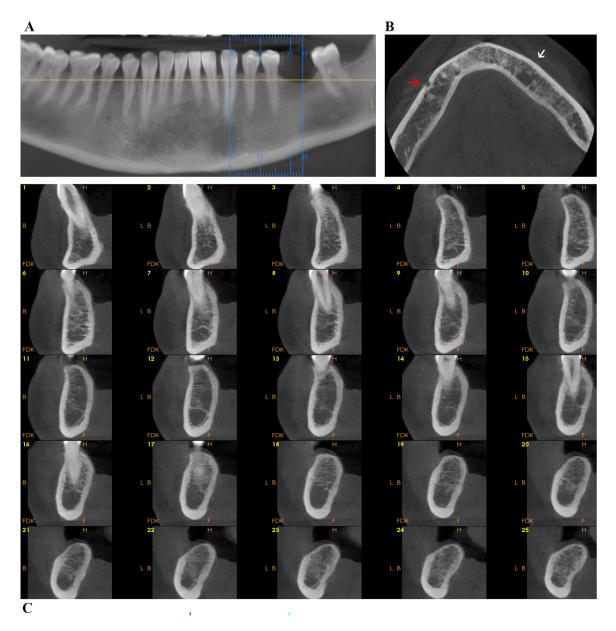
(A) Reformatted panoramic view. (B) CBCT axial view demonstrating the absence of the left-side mental foramen (white arrow) in contrast to its presence on the right side (red arrow). (C) Cross-sectional series of the left mandibular body showing no visible exit of the mental bundle along the buccal wall.
